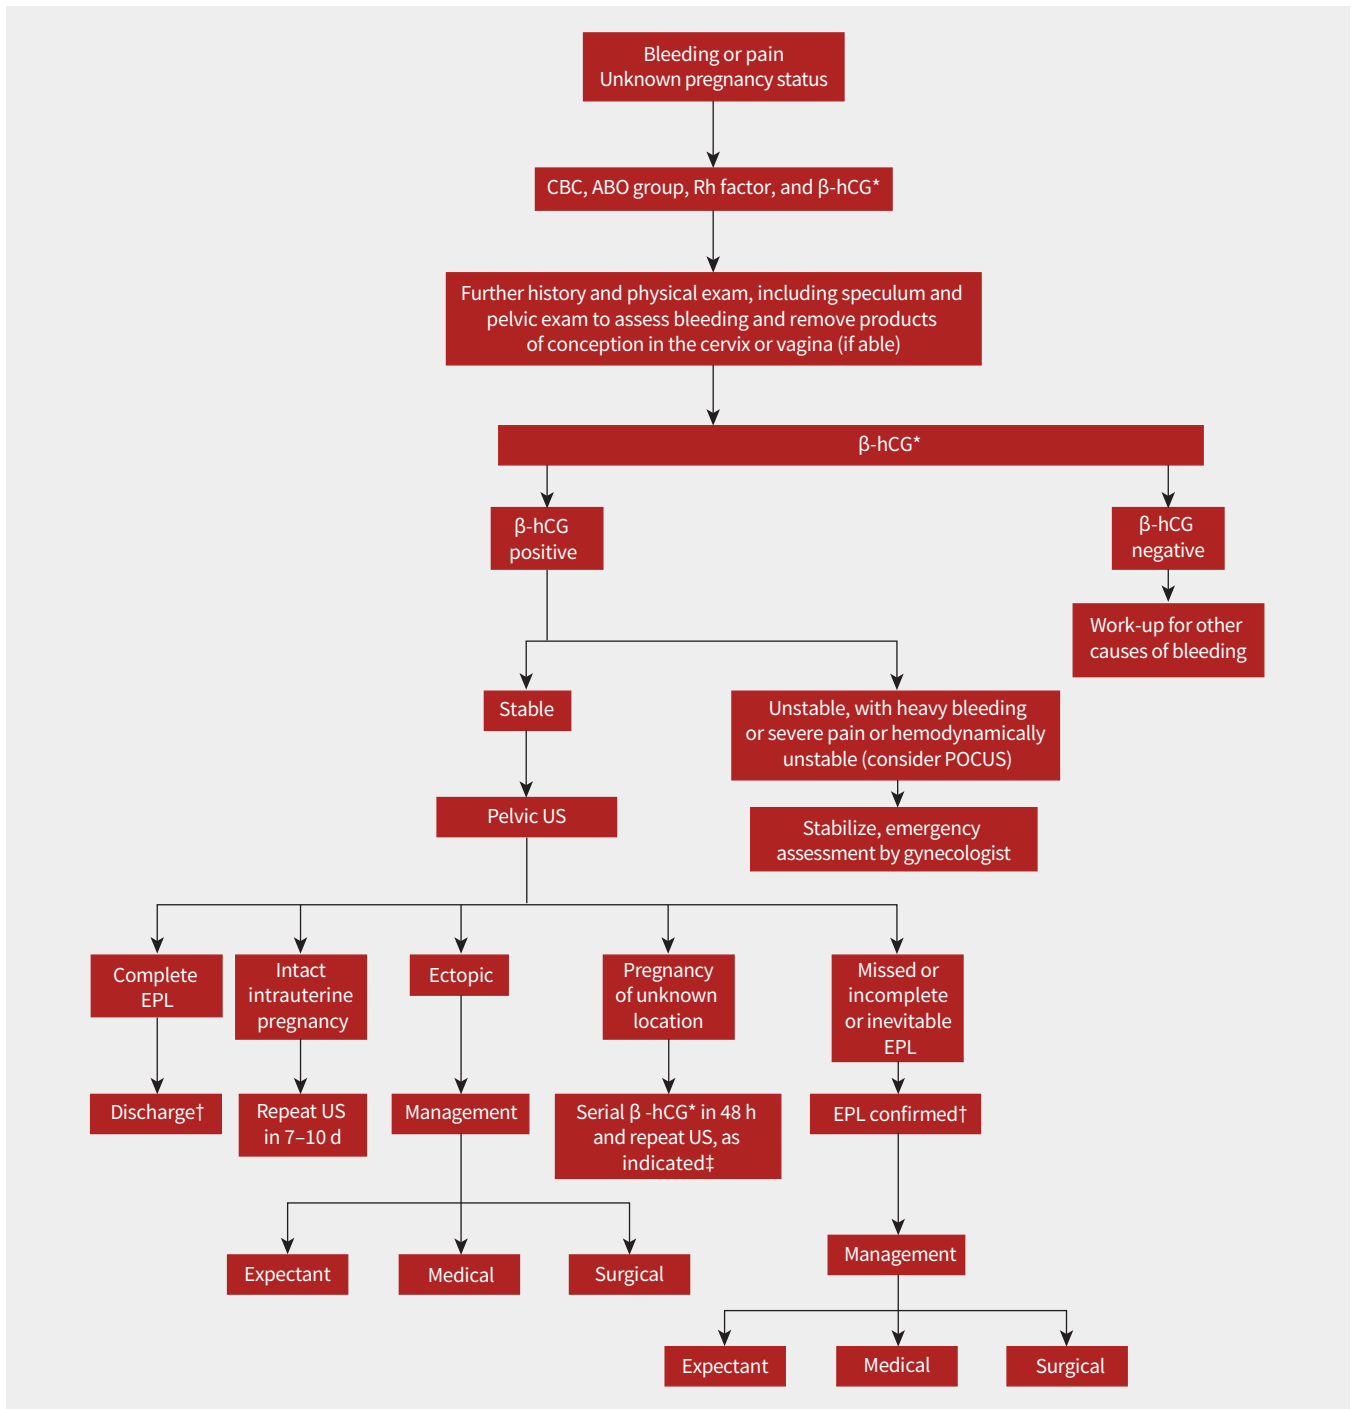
Diagnosis of early pregnancy loss. *Quantitative β -human chorionic gonadotropin (β -hCG) is preferred if available, but qualitative or urine β -hCG can be used if a quantitative measure is unavailable. †Patient should be offered patient-centred compassionate treatment and resources in the community. ‡The ratio of repeat β -hCG to initial β -hCG can stratify risk of ectopic pregnancy and will determine the need and timing of serial ultrasonography. See Related Content tab for accessible version. Note: CBC = complete blood count, EPL = early pregnancy loss, POCUS = point-of-care ultrasonography, US = ultrasonography.
